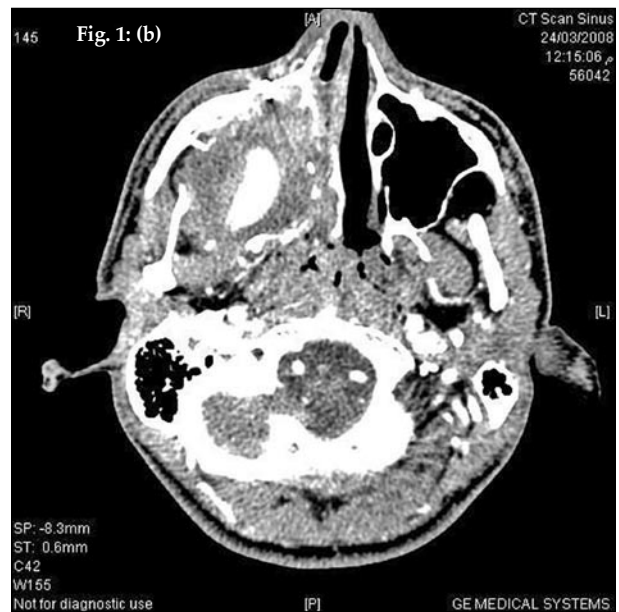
(a) Pre and (b) post-contrast CT of the nose-sinuses demonstrating the presence of a tubular enhancing lesion in the right maxillary sinus
